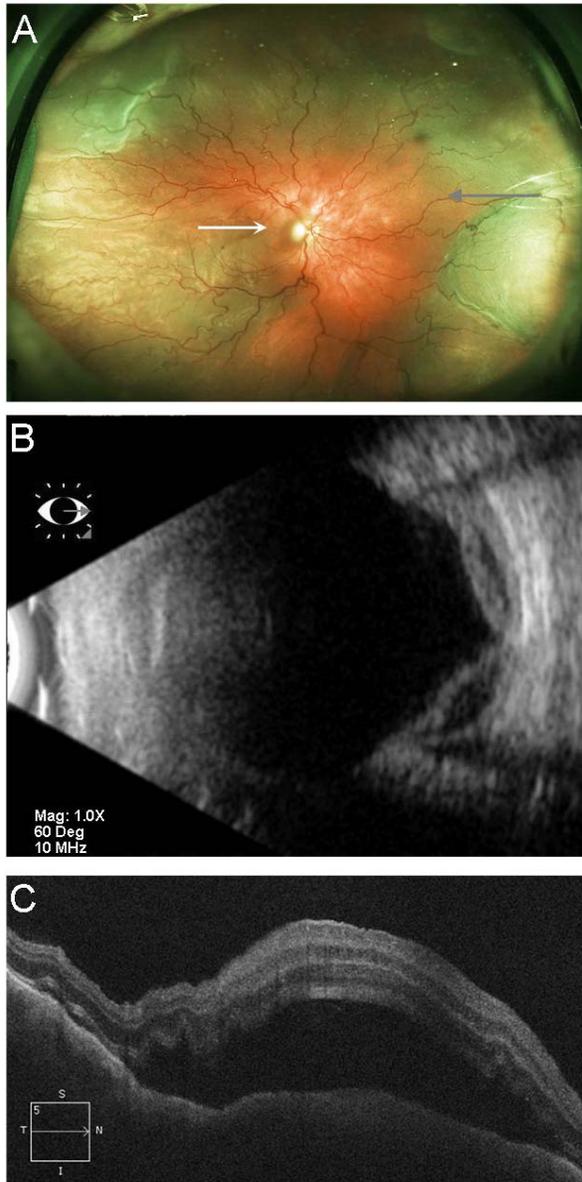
Choroidal effusions from presumed compression of the vortex veins by post-operative day 3 after nasal transposition of the split lateral rectus muscle. A. Wide-field fundus image of the right eye showing peripheral choroidal effusions circumferentially. B. B-scan ultrasonography of the nasal posterior segment of the right eye. The gray arrow in (A) shows the direction of the scan with the back of the arrow indicating the top of the ultrasound. C. Optical coherence tomography showing the choroidal effusions extending into the macular region. The white arrow in (A) shows the location of the scan.
